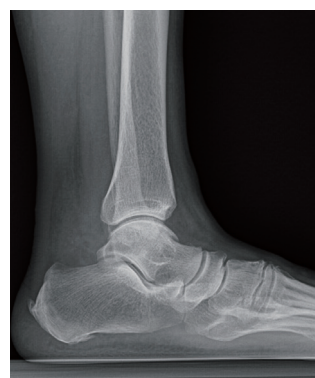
The lateral radiograph of the left tibia had no sign of fracture (Feb 1<sup>st</sup>).
